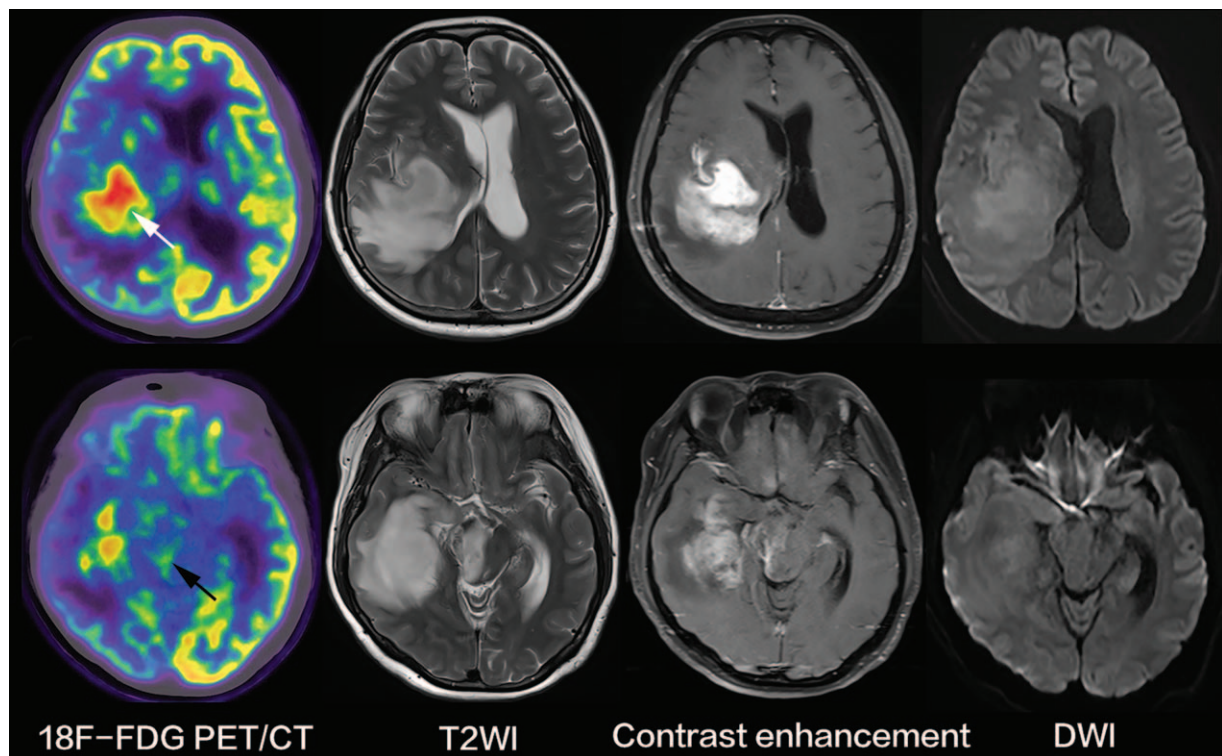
Multicentric gliomas. A lesion (white arrow) located at the junction of the right frontal and parietal lobes exhibited higher metabolism on ^{18}F -FDG PET findings than normal gray matter. The lesion exhibited hyperintensity on T2-weighted MR images and obvious inhomogeneous contrast enhancement and restricted diffusion on diffusion-weighted MR images (upper row). Another lesion in the mid-brain (black arrow) exhibited much lower metabolism than the above lesion on ^{18}F -FDG PET findings and similar manifestation on MR images (lower row).
